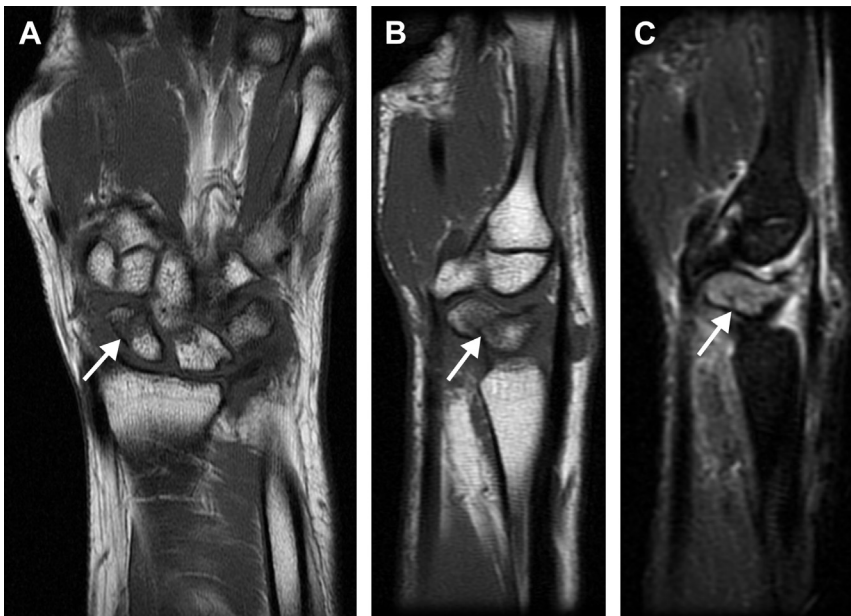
Occult scaphoid fracture. (A) Coronal T1-weighted image shows linear hypointense fracture lines in the scaphoid waist. (B) In this case the fracture line is better seen on sagittal T1 images. (C) Sagittal T2 FS images show diffuse increased signal in the scaphoid consistent with bone edema and surrounding soft tissue edema.
